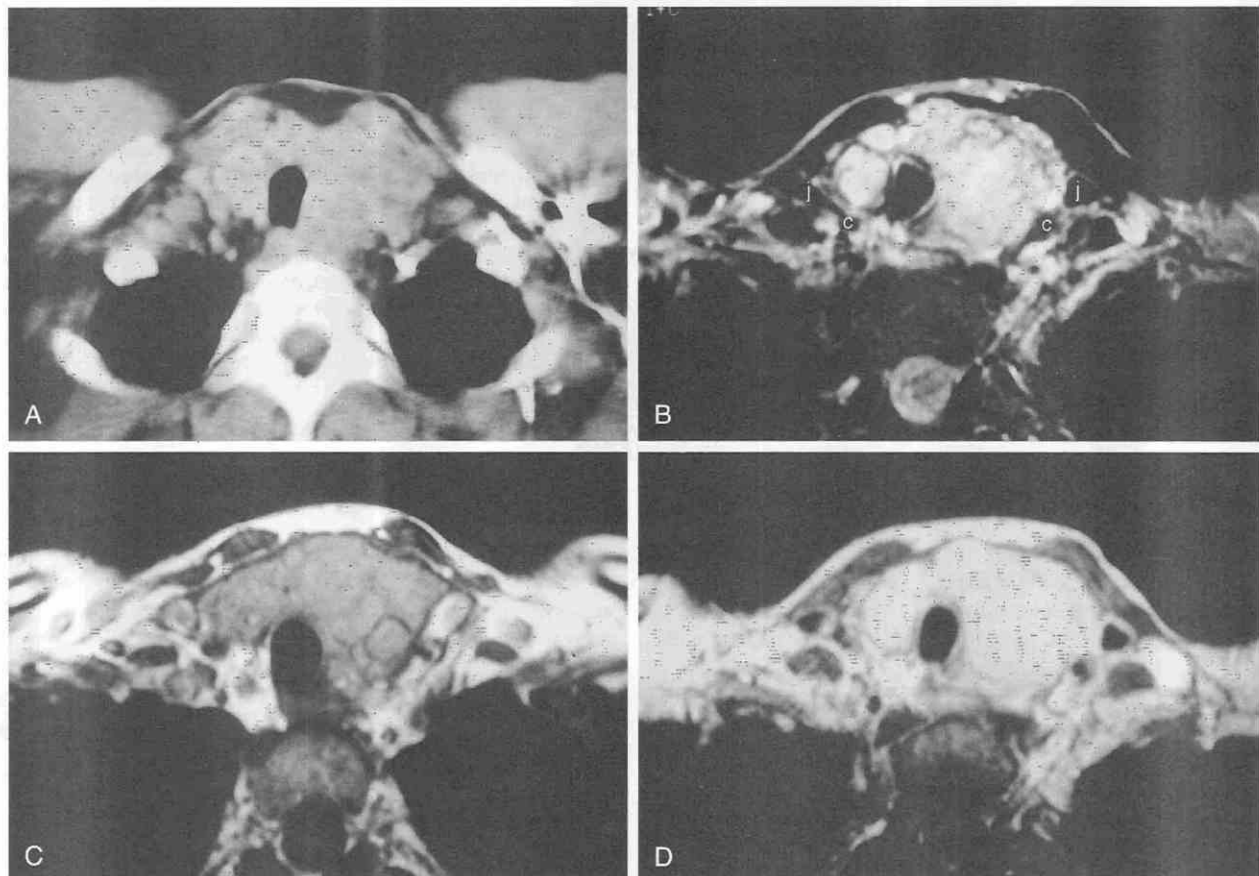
A, Axial CT image shows a lobular mass arising from the left lobe of the thyroid; it has a slight mass effect on the trachea. B, Axial T2-weighted MR image demonstrates a predominantly hyperintense mass splaying the bilateral common carotid arteries (c) and internal jugular veins (j). There is no evidence of tracheal invasion. C, Axial T1-weighted MR image demonstrates that the mass is of intermediate signal intensity. D, Axial T1-weighted MR image after contrast administration shows diffuse enhancement throughout the mass. Follicular carcinoma without tracheal invasion was seen at surgery.
